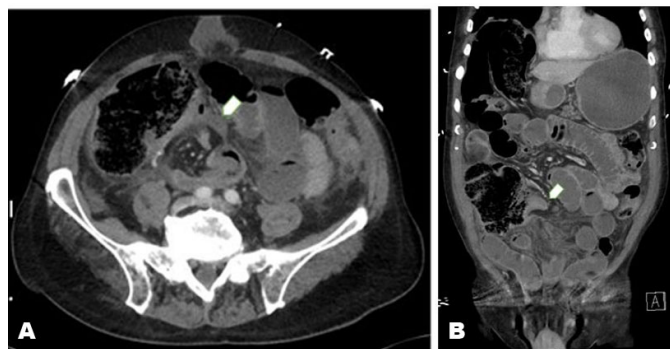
(A and B): Computed tomography (CT) with intravenous contrast (axial view and coronal view). Arrow shows the appendix forming a band through which terminal ileum passes, forming a closed loop obstruction.
